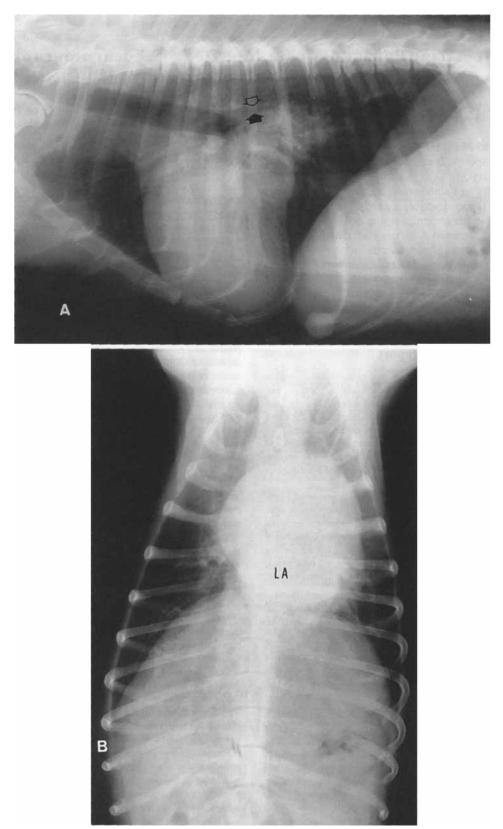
(A) Right lateral radiograph. The dorsocaudal border of the heart is enlarged in the region of the left atrium and the left mainstem bronchus is compressed (arrows). (B) Dorsoventral radiograph. The left atrium (LA) is more radiopaque than normal.
